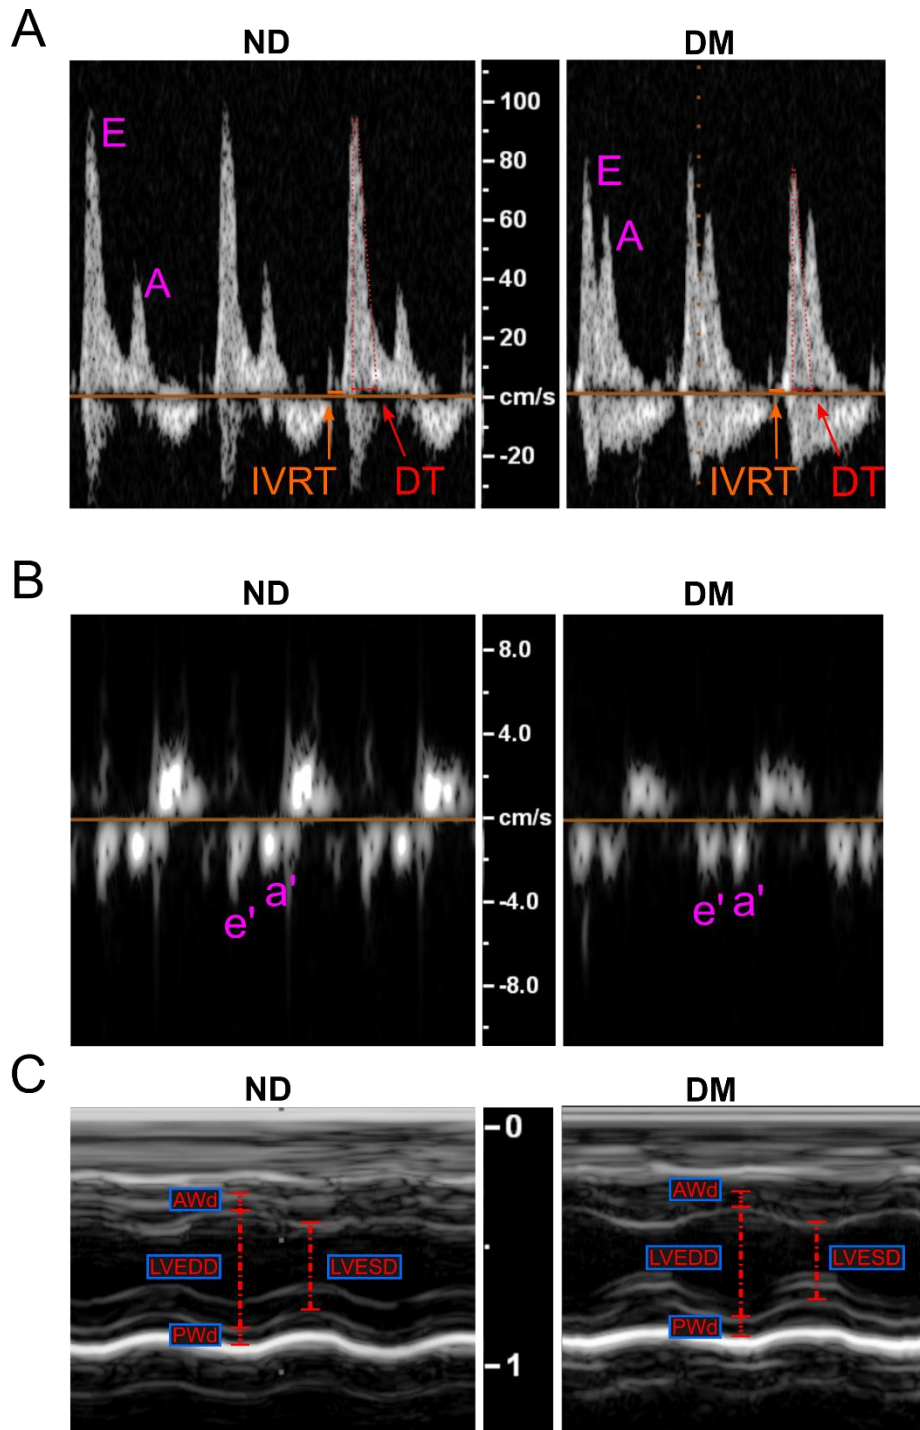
Representative echocardiography images including method of parameter measurement. E = blood flow during early phase of diastole, A = late atrial phase of diastole, e' = early mitral valve velocity during diastole, a' = late mitral valve velocity during diastole, IVRT = isovolumic relaxation time, DT = deceleration time, AWd = anterior wall dimension, LVEDD = LV end-diastolic dimension, PWd = posterior wall dimension, LVEDS = LV end-systolic dimension.
